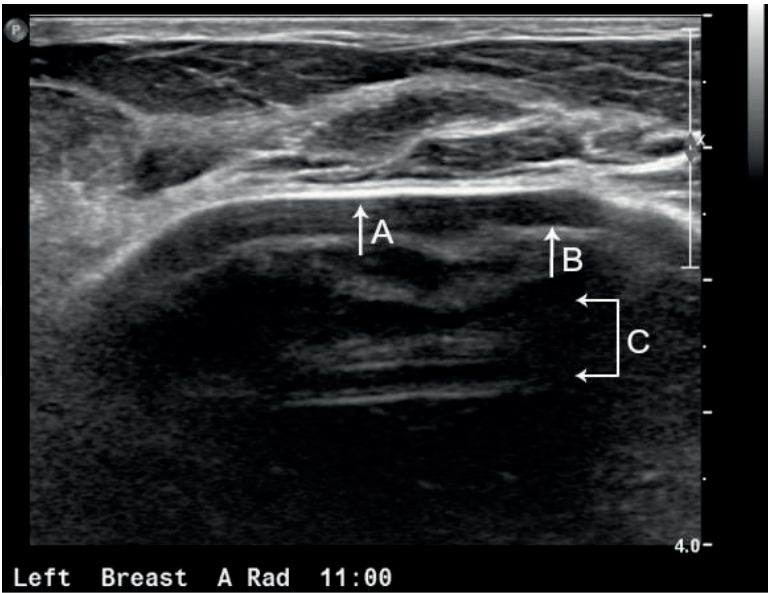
“Stepladder sign.” Transverse ultrasound demonstrates an intracapsular silicone implant rupture. (A) Outer capsule, (B) shell of collapsed implant, and (C) “Linguine sign”.
